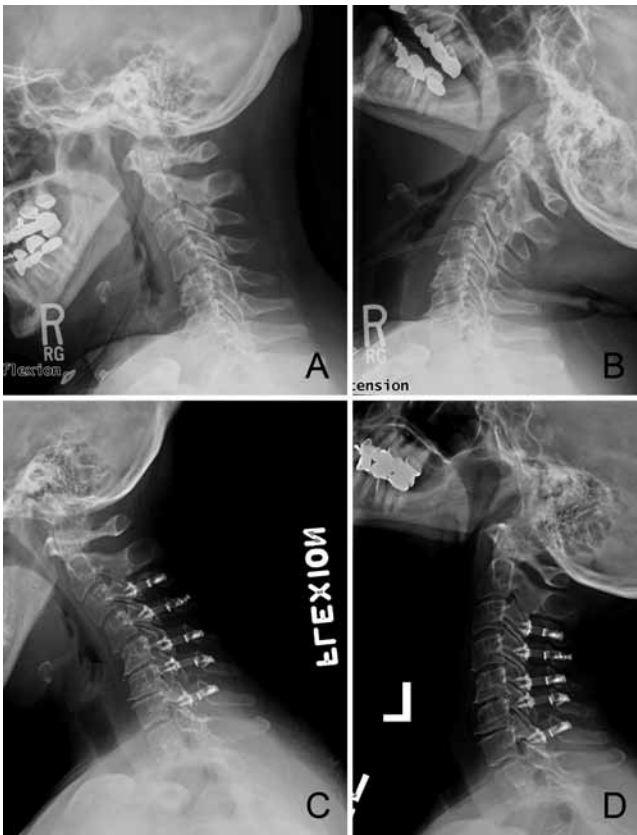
Dynamic (flexion and extension) lateral radiographs of the cervical spine. A: Preoperative flexion. B: Preoperative extension. C: Postoperative flexion. D: Postoperative extension.
